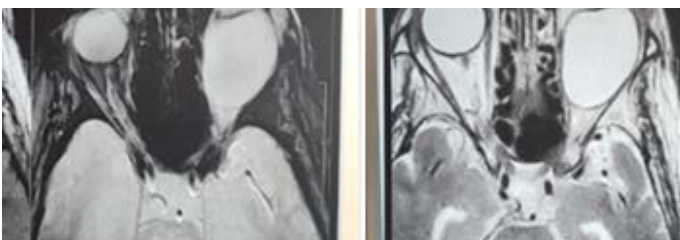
Orbital MRI : Extra conical intraorbital cystic formation with thin and regular wall in hyposignal on all sequences not enhanced after gadolinium injection measuring 35x28x27 mm, the content is in T1 hyposignal, T2 hypersignal disappearing on the FLAIR sequence without restriction of dissidence or enhancement after injection of gadolinium this mass exerts a mass effect on the intraorbital structures (the eyeball, the superior rectus muscle and the optic nerve).
